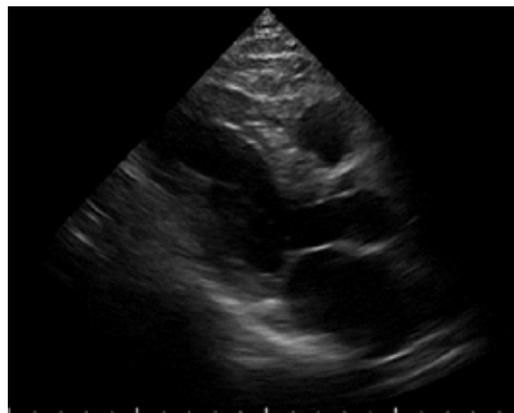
Long parasternal axis image.
